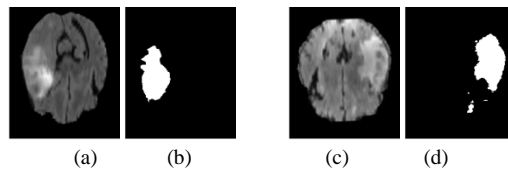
(a)(c) Slices sampled from two 3D MRI brain images of Flair modality. (b)(d) Binary tumor masks of the slices in (a) and (c).
